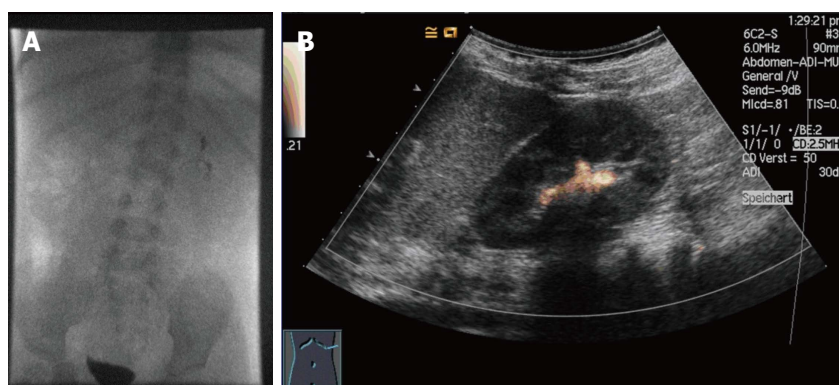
Voiding cystourethrography (A) vs voiding urosonography (B) of a two-year-old male patient with proven vesicoureteral reflux left at the left kidney (grade II). The voiding urosonography scan shows the urosonography contrast agent microbubbles in the left renal pelvis (agent detection mode).
